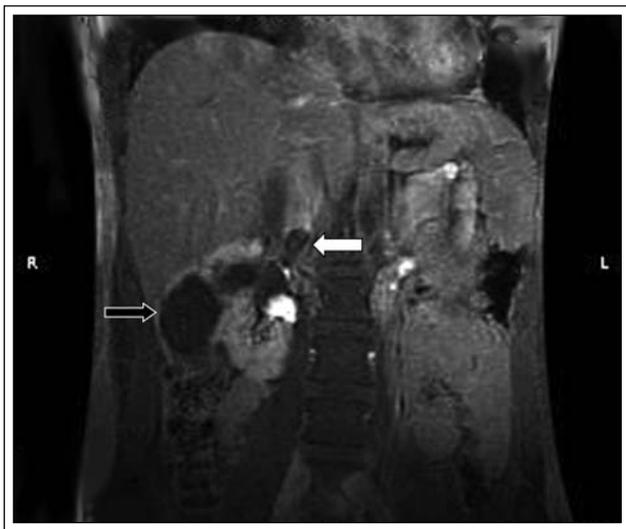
Coronal-reconstruction of abdominal MRI demonstrating a large 9 cm, fat containing lesion of right kidney (black arrow) with invasion into infrahepatic inferior vena cava (white arrow).
